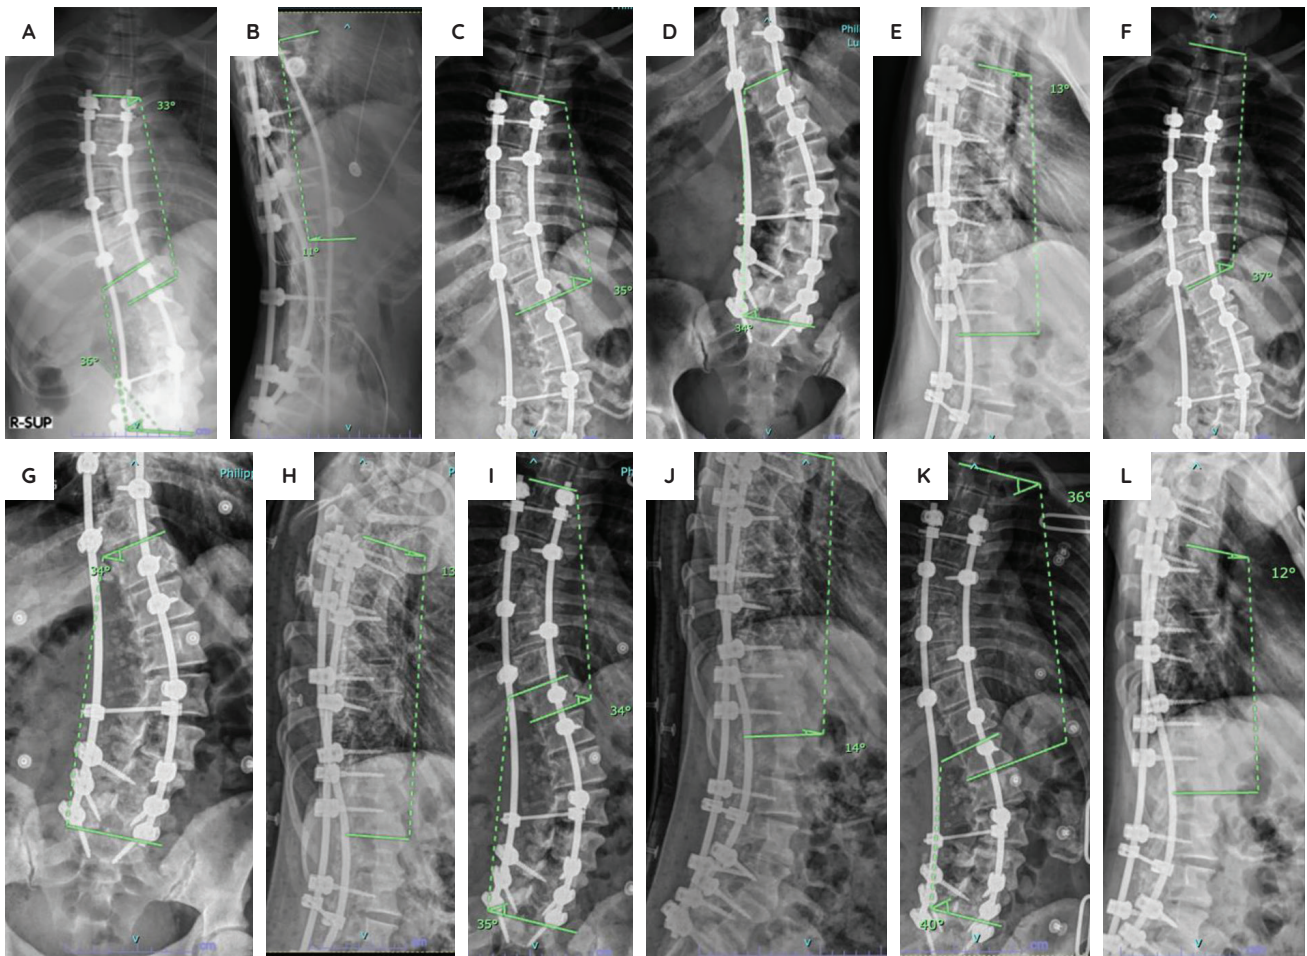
Patient B postoperative radiographs. Standing AP and lateral xrays of Patient B two weeks postoperatively, with intact fixation and no screw pullouts (A and B). Standing AP and lateral xrays of Patient B one month postoperatively showing loss of correction of the thoracic curve of proximal thoracic curve by 2 degrees, maintained thoracolumbar/lumbar curve, and an increase of kyphosis by 2 degrees, but still within normal limits (10–40 degrees) (C, D, E). Standing AP and lateral xrays of Patient B three months postoperatively showing loss of correction of the thoracic curve of proximal thoracic curve by 4 degrees, maintained thoracolumbar/lumbar curve, and kyphosis within normal limits (F, G, H). Standing AP and lateral xrays of Patient B six months postoperatively maintained correction of the proximal thoracic curve, thoracolumbar/lumbar curve, and kyphosis (I and J). Standing AP and lateral xrays of Patient B 12 months postoperatively showing loss of correction of the proximal thoracic curve by 3 degrees and thoracolumbar/lumbar curve by 4 degrees, and maintained kyphosis (K and L).
